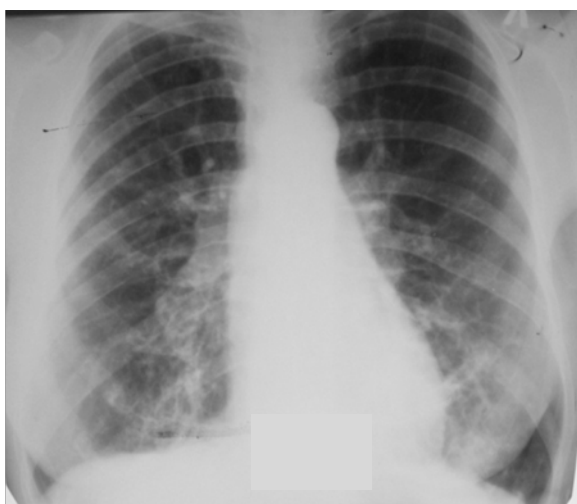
Chest radiograph. Frontal view. Diffuse bilateral reticular – mesh like appearance, more in basal parts of pulmonary fields. Chronic bronchitis
